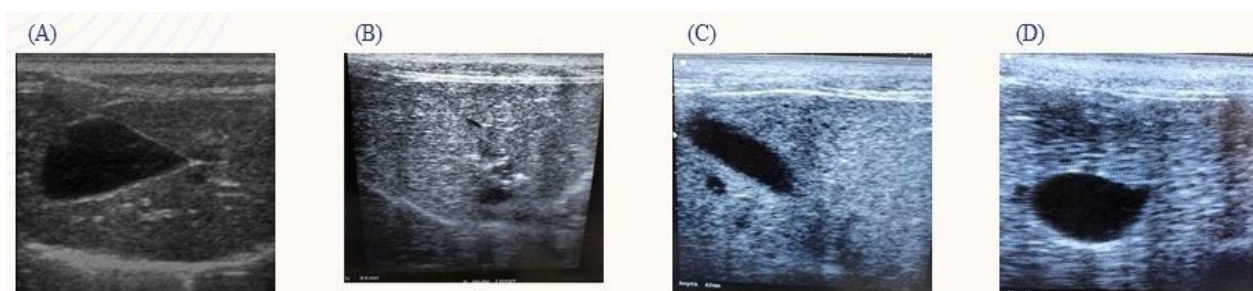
A) Ultrasonographic picture of Silymarin treated Group II on day 21 showing moderate echoic hepatic parenchyma and anechoic gall bladder and average wall thickness which look to be nearly normal texture. B) Ultrasonographic picture of liver in l-carnitine treated group III on day 21 showing slight increase in echogenicity and anechoic gall bladder compared with day 0. C) Ultrasonographic picture of liver in liquorice treated group IV on day 21 showing more increase in echogenicity of liver parenchyma compared with silymarin treated group II and l-carnitine treated group III.
